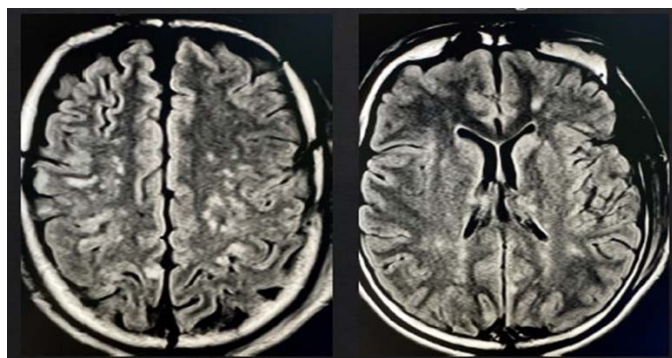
Magnetic resonance imaging (MRI) showing multifocal and non-confluent lesions changed hypersignal in the weighted sequence in FLAIR and diffusion restriction signs, compromising the white matter of the frontal and parietal lobes bilaterally. Source: Hospital Santa Isabel.
